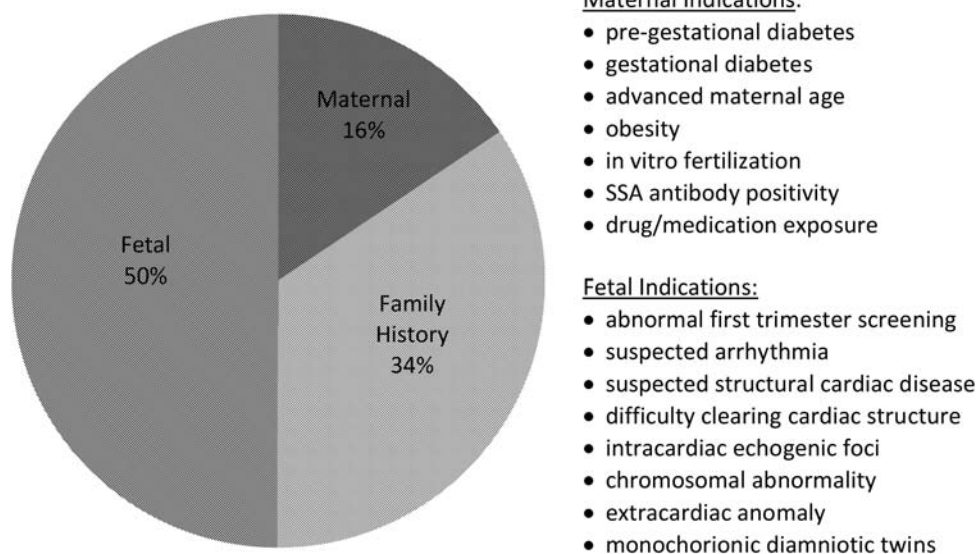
Reason for referral to Seattle Children's Hospital Regional Clinics for screening fetal echocardiogram (n = 699)
